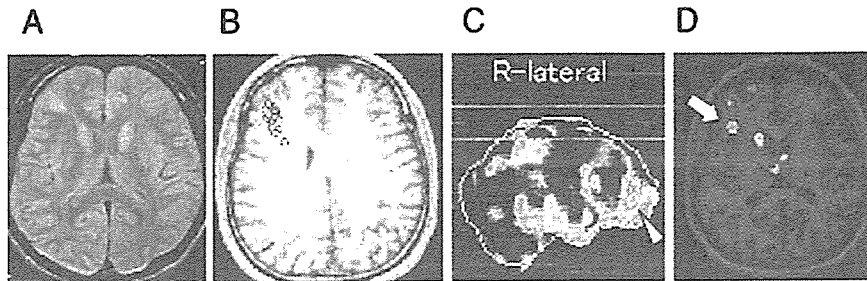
Magnetic resonance imaging (MRI), magnetoencephalography (MEG), and single-photon emission computed tomography (SPECT) findings: Case 7. A: Proton density-weighted MRI: High-intensity areas are seen in the right frontotemporal and the left frontal lobes. B: MEG: An equivalent current dipole (ECD) cluster (yellow) is detected adjacent to and surrounding a single tuber in the right frontal lobe. C, D: Ictal SPECT: On simple ictal SPECT, no hyperperfusion area is recognized (data not shown). However, after processing of original images by using 3D-SSP (C) or SISCOM (D) technology, a hyperperfusion area, indicated by a *white arrowhead* (C) and a *white arrow* (D), emerged in the right frontal lobe. These images are spatially consistent with the location of an ECD cluster on MEG.
